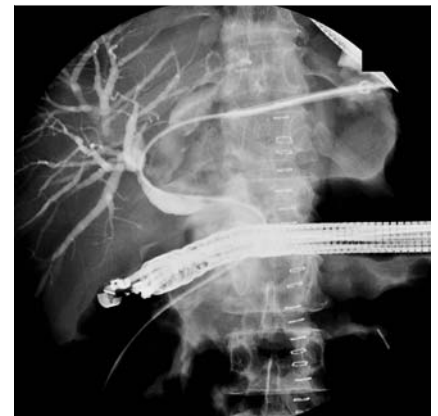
Passage of the guidewire by percutaneous transhepatic cholangiography, through the common bile duct and into the duodenum via the bilioduodenal access previously created under endoscopic ultrasound (EUS).
